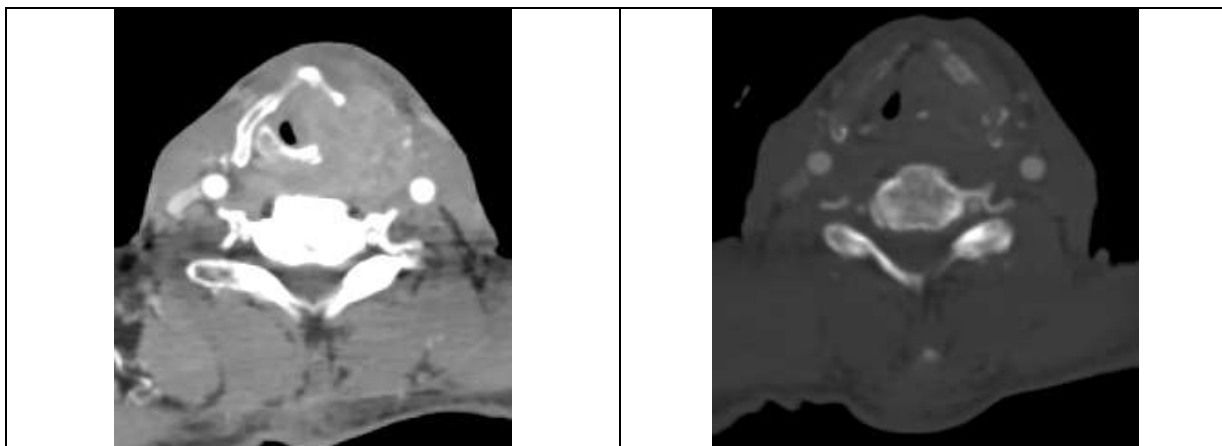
(a) and 6(b): Axial CECT and CT bone images at the level of thyroid cartilage in a case of Ca Glottis shows invasion of left thyroid cartilage with penetration into extralaryngeal space.
